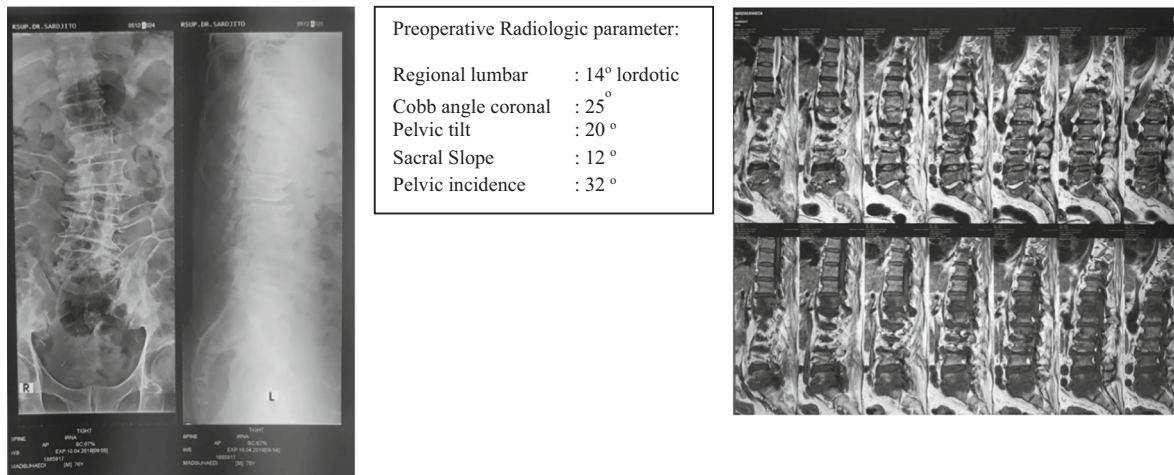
Case 3 Initial radiograph presentation.
